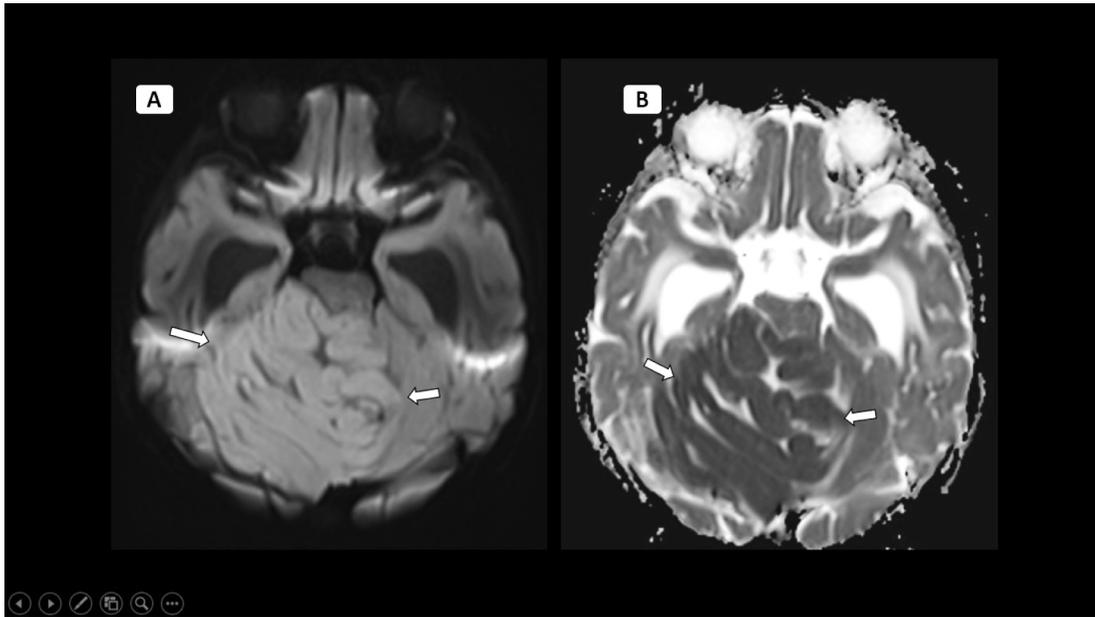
MRI brain images in axial DWI (A) and ADC (B), of the mass showing high signal on DWI and low signal on ADC map, compatible with restricted diffusion indicating high cellularity (white arrows).
